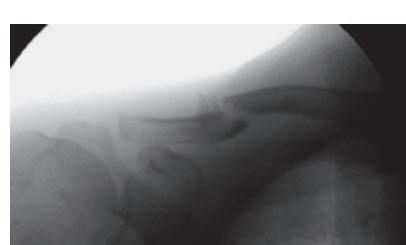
X-ray demonstration of Cephalad tilting of C-arm.
